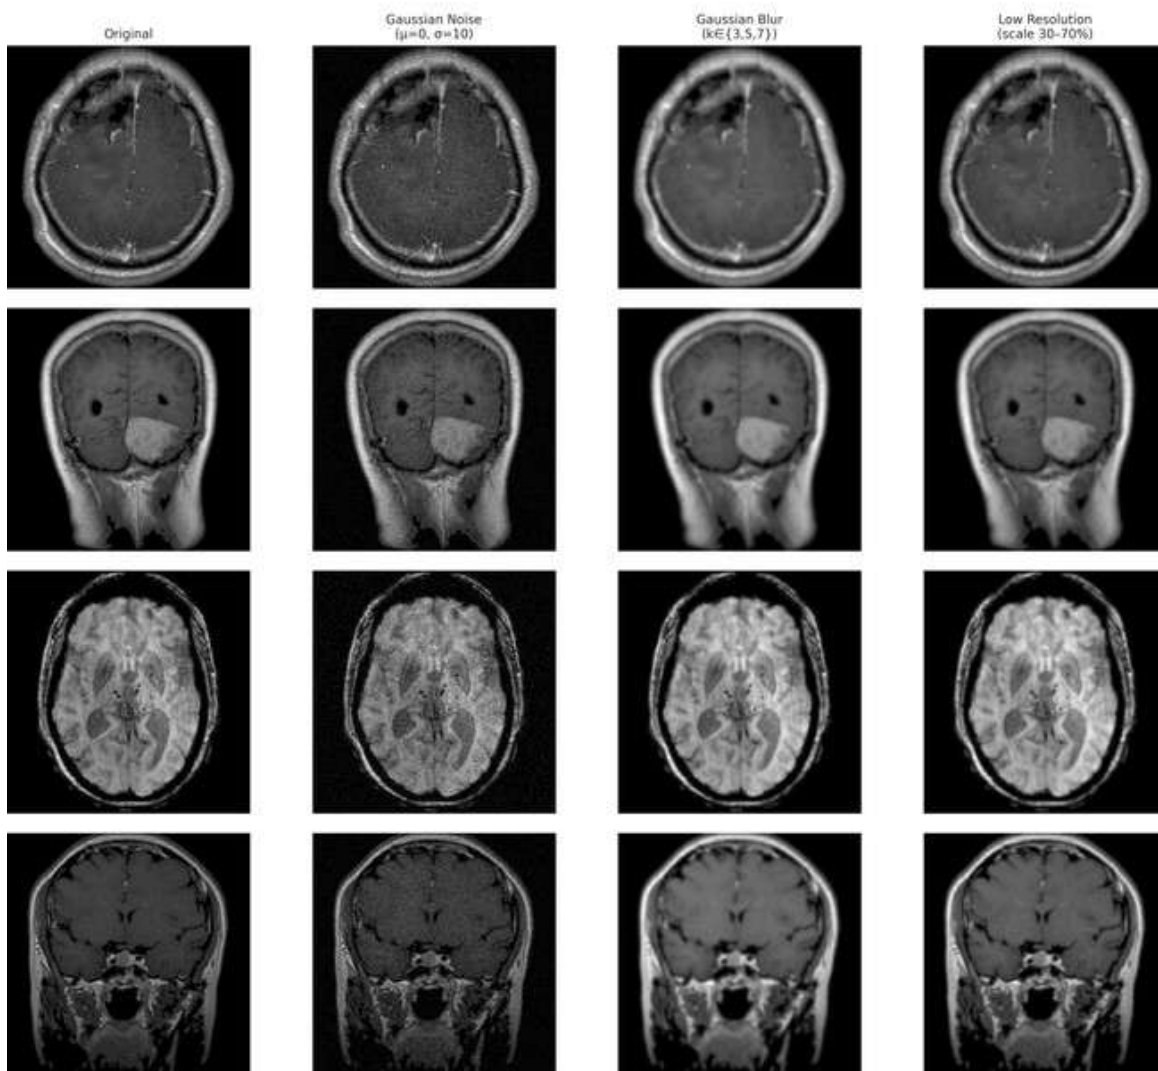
MRI augmentation comparison across all four classes. Columns: original, Gaussian noise ( $\sigma=10$ ), Gaussian blur ( $k \in \{3, 5, 7\}$ ), resolution degradation (scale 30–70%). All augmented samples maintain SSIM  $\geq 0.85$ .
